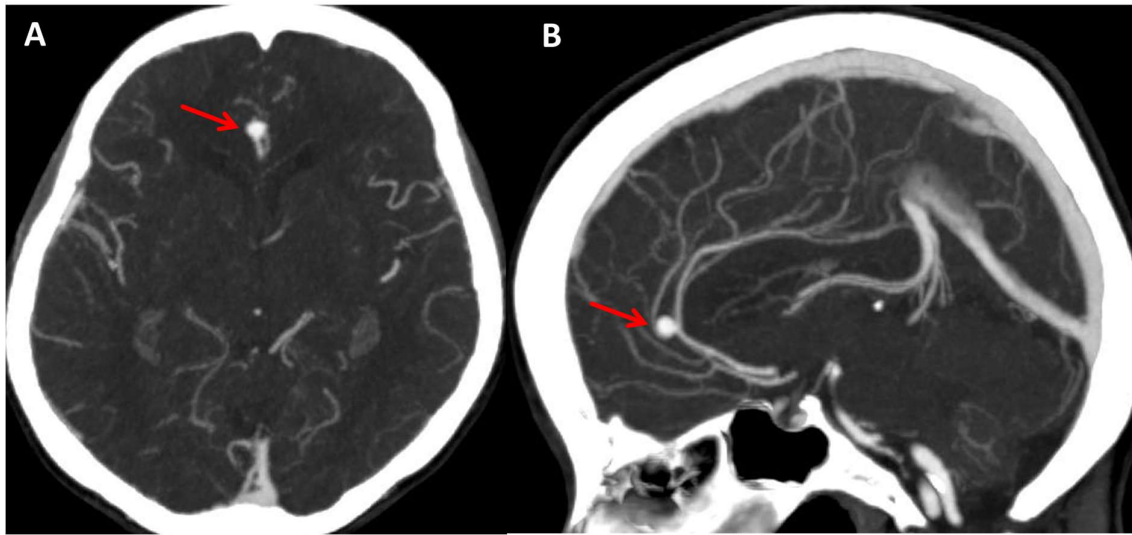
Cerebral CT angiogram in axial (A) and sagittal (B) planes showing the new saccular aneurysm at the right distal ACA (red arrow).
